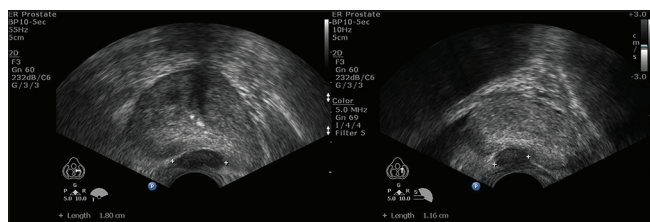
A hypoechoic nodule 1.8 cm × 1.1 cm in size was fixed within the left lobe peripheral zone of the prostate in the findings of transrectal ultrasonography
